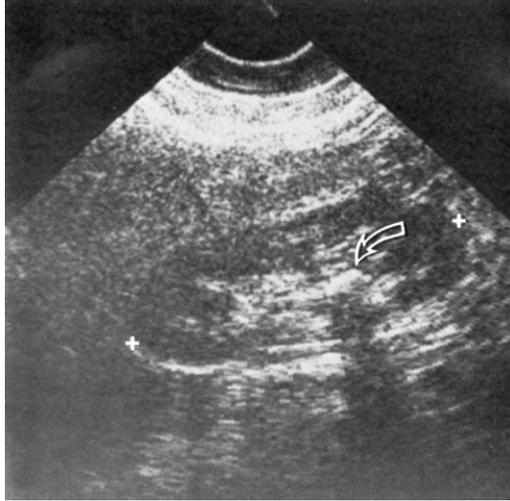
Renal stone. Longitudinal view of kidney containing a hyperechoic calculus (*open arrow*) with posterior acoustic shadowing. (From Van Arsdalen KN, Banner MP, Pollack HM. Radiographic imaging and urologic decision making in the management of renal and ureteral calculi. *Urol Clin N Am* 1990;17:186; with permission.)
